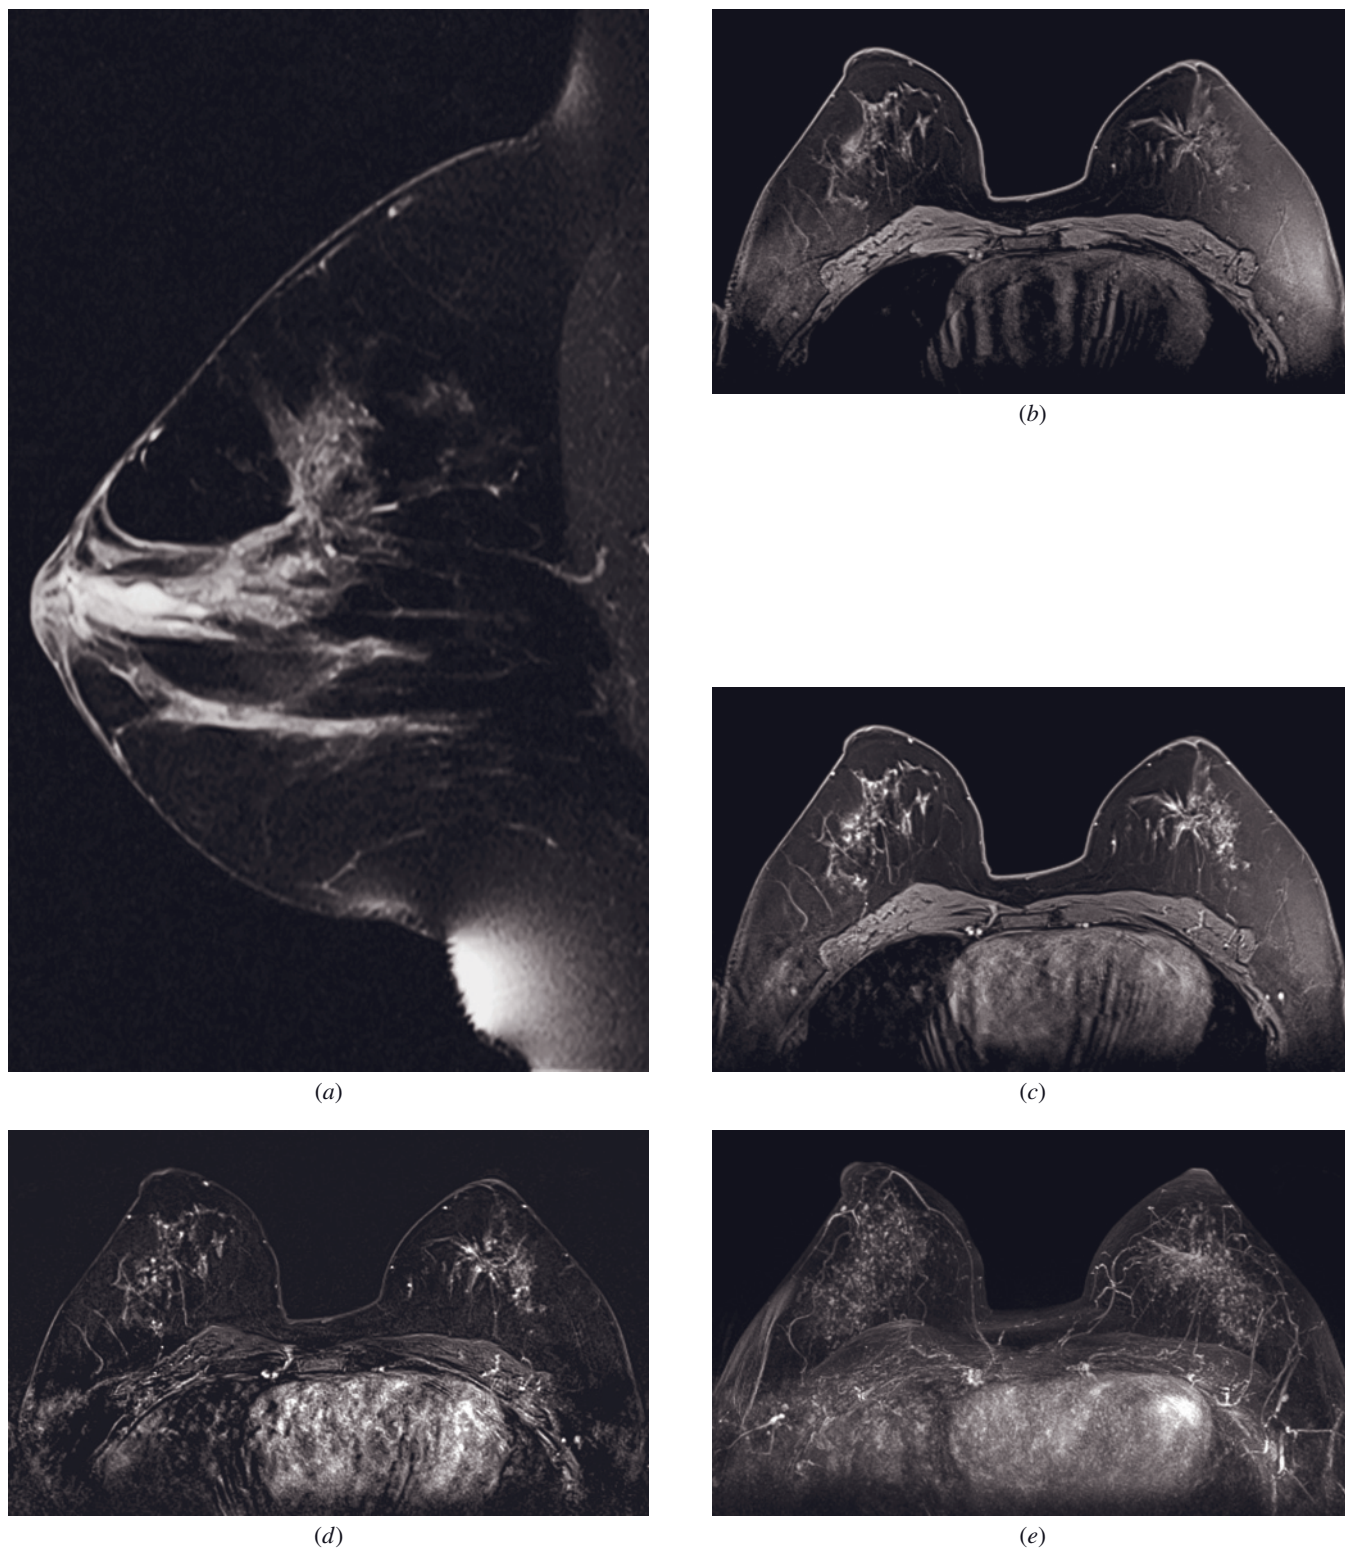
Adenosclerosis. Sagittal fat-saturated T2-weighted (*a*) and axial GRE (*b*) images show an isointense lesion with long, radially distributed spicules in the upper inner quadrant of the left breast (BI-RADS 4 lesion). There is no significant enhancement on postcontrast GRE (*c*) and subtracted (*d*) images. Only architectural distortion with MRI background enhancement type 3 of the breast parenchyma is seen on the MIP image (*e*). Excisional biopsy revealed blunt duct adenosis (adenosis partim atypica).
